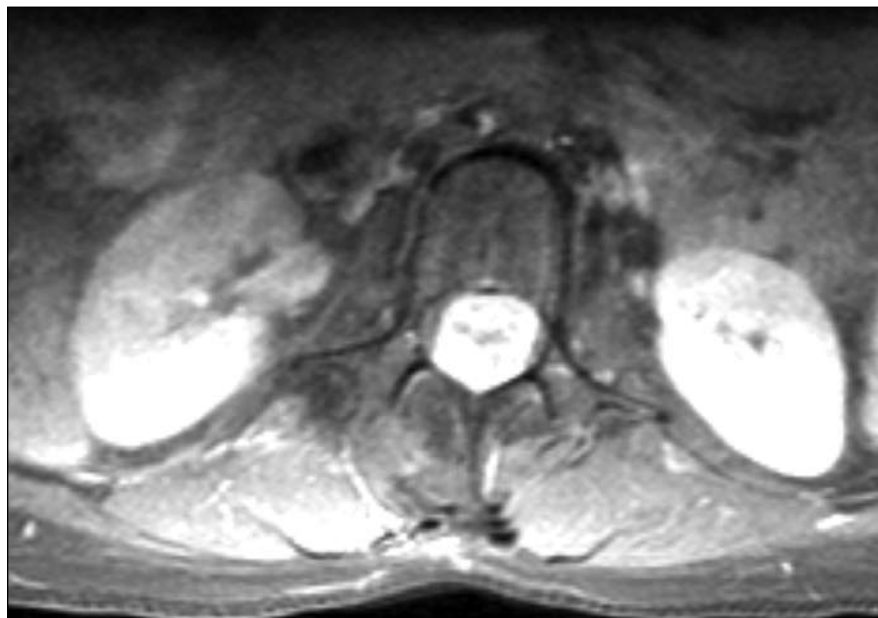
Axial T1 MRI lumbar spine MR Imaging post gadolinium at the level of L1 showing the intradural mass. The entire spinal canal is occupied by the heterogeneously contrast enhancing mass.
